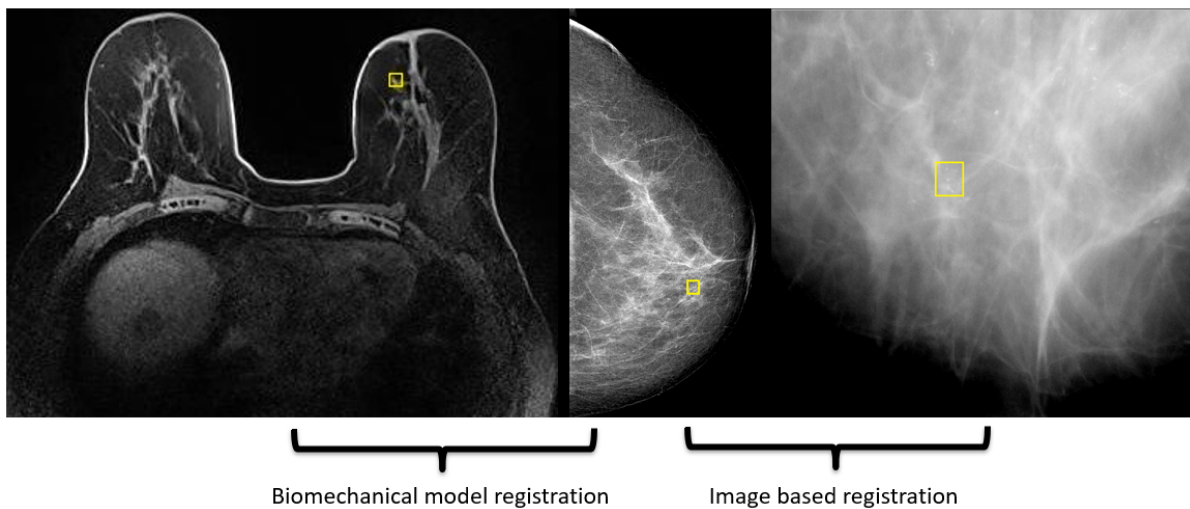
Two step image registration between MRI and spot mammograms for X-ray guided stereotactic breast biopsy. To register MRI (left) with full view mammograms (middle), a biomechanical model based registration is used. To register spot mammograms (right) with full view mammograms (middle), an image based registration is applied. Yellow rectangles indicate the marked lesions in all modalities by an expert radiologist (160).
